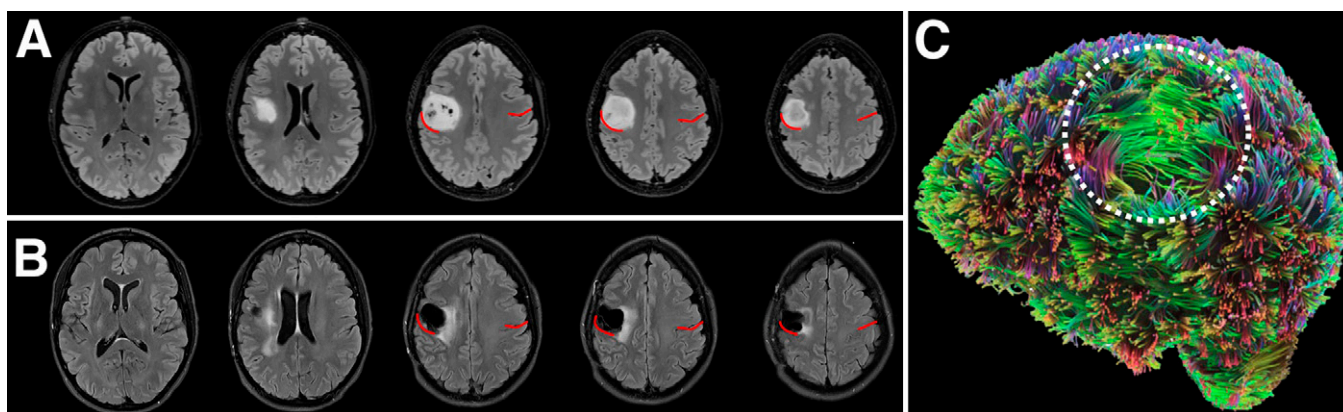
Pre- and postoperative imaging of the patient's tumor and resection. A: Preoperative fluid-attenuated inversion recovery (FLAIR) imaging showing the patient's tumor prior to surgery (hyperintense/bright). Red lines indicate central sulcus. B: Eleven-month postoperative FLAIR imaging showing the patient's resection (hypointense/dark). Red lines indicate central sulcus. C: Diffusion tensor imaging of the patient's brain prior to surgery. Note the impact of the tumor on the fibers of the superior longitudinal fasciculus, circled in white.
